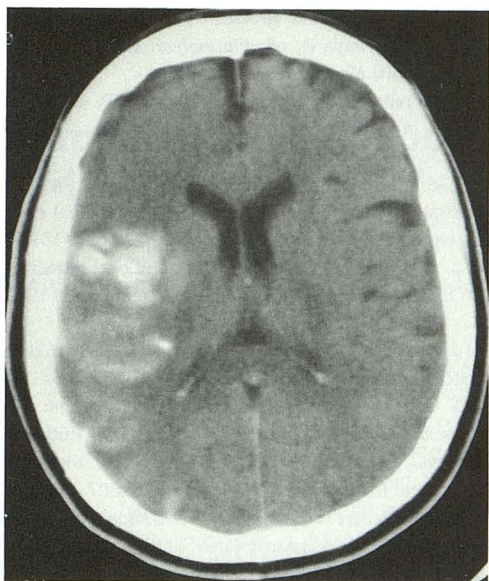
Patient 9. Noncontrast axial CT. There is parenchymal and/or subarachnoid material of high attenuation (170 to 184 HU) in the treated territory of the right middle cerebral artery. The hounsfield units are too high to represent blood alone and are probably contrast mixed with blood. An initial decline in clinical status was followed by a significant clinical improvement.
